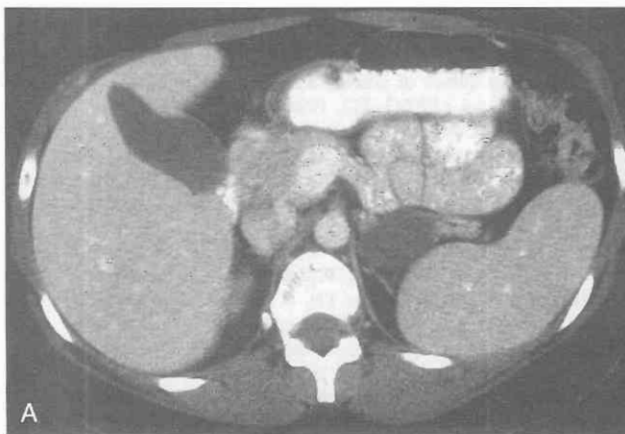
Adrenal cyst. A, Contrast-enhanced CT scan of the abdomen reveals a 3-cm cyst in the left adrenal gland. B, Percutaneous sclerosis of the cyst was performed from a posterior approach. C, Follow-up CT scan demonstrates ablation of the left adrenal cyst.
